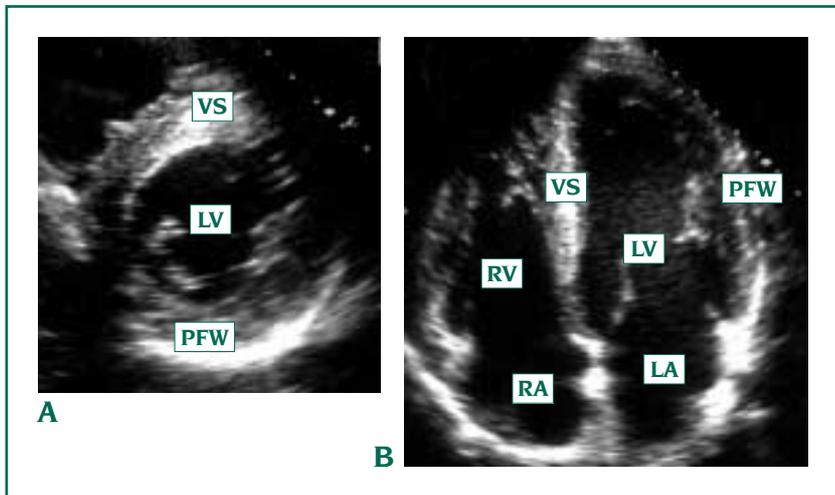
Parasternal short axis (A) and apical 4-chamber (B) echocardiographic views of the heart in the same athlete as in Figure 2, showing normal cardiac dimensions and absence of structural abnormalities (left ventricular end-diastolic cavity dimension = 52 mm, maximum ventricular thickness = 11 mm). Calibration dots are 1 cm apart.
